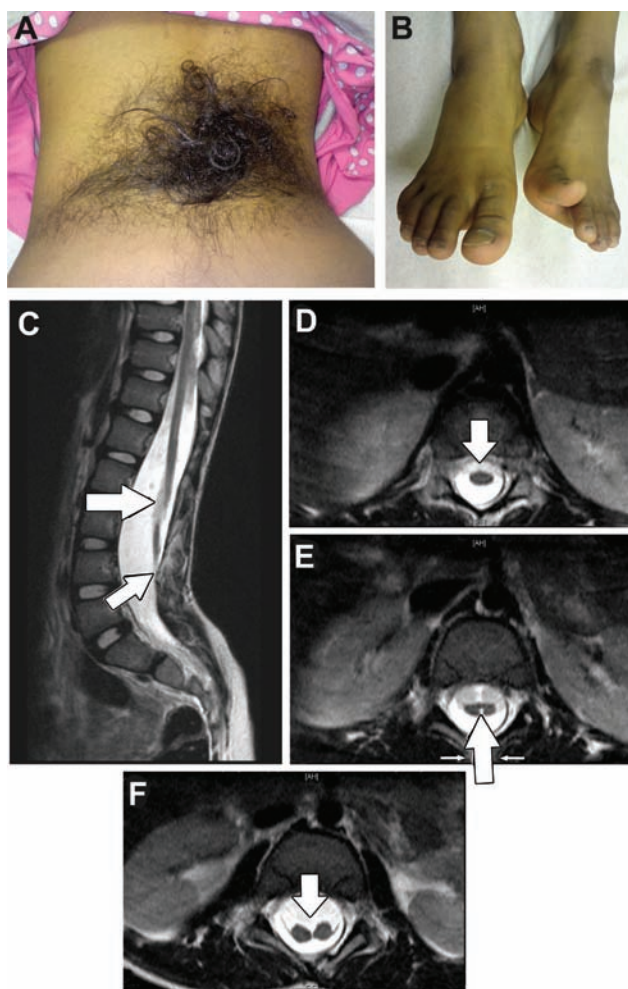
Images showing: A) a 9-year-old girl presenting with a remarkable hair tuft at the back above the gluteal fold; B) the left foot was smaller, had equinus posture, and showed spontaneously upgoing big toe; C) sagittal T2-weighted MRI showed features of diastematomyelia with thinning of the spinal cord (large arrow) resulting from the intervening subarachnoid space between the 2 hemicords. There is also remarkable widening of the spinal canal with tethering of the cord (small arrow). D-F) serial axial T-2 weighted images revealed that the spinal cord started to divide at the level of L2 (E) into 2 halves (F).
